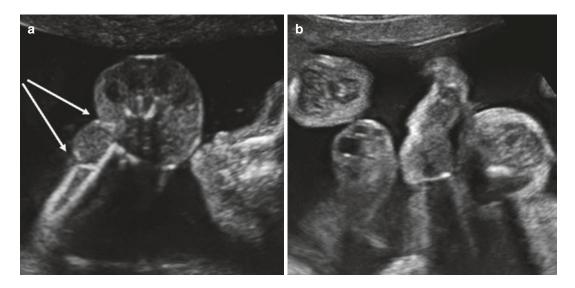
Limb in Amniotic band syndrome. (a) Right forearm at 23 weeks: significant edema at the distal part and visualization of two notches created by the amniotic band (*arrows*). (b) Ultrasound image of the right arm and hand 1 month after fetoscopic release of the band. There
